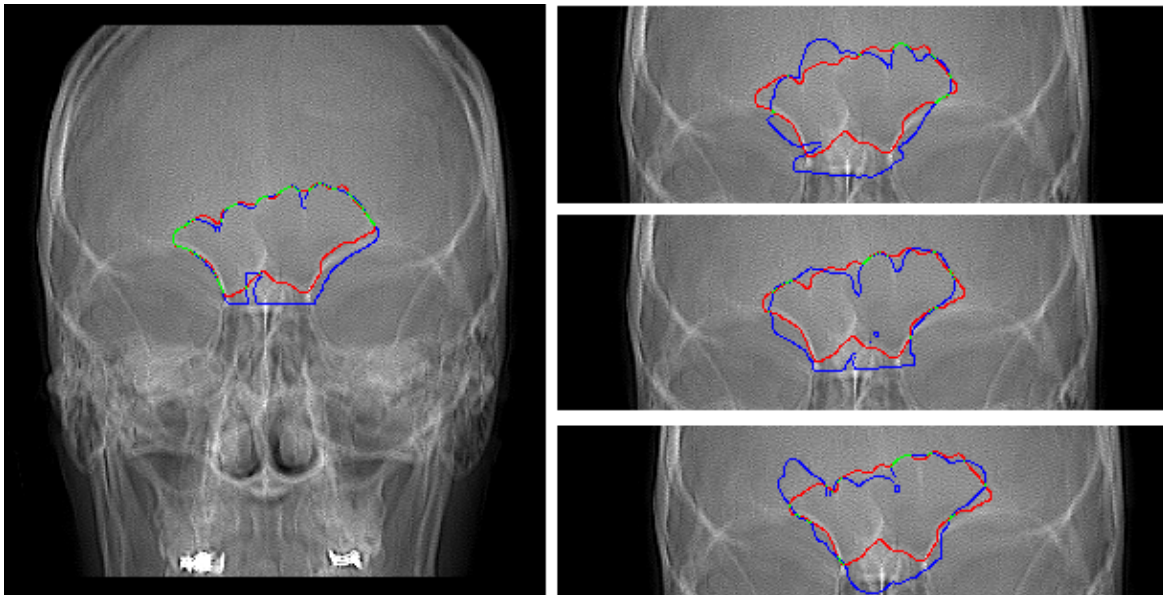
(Left) An example of a positive case, radiograph *A* compared against CT *A*; (Right) Example of negative cases, radiograph *A* compared against CTs *B*, *C*. Red lines display the segmented X-ray AM image, blue lines represent the projected 3D PM image (i.e., the registration result, or silhouette that we try to align to the red one), green lines represent perfect overlap between red and blue lines.
